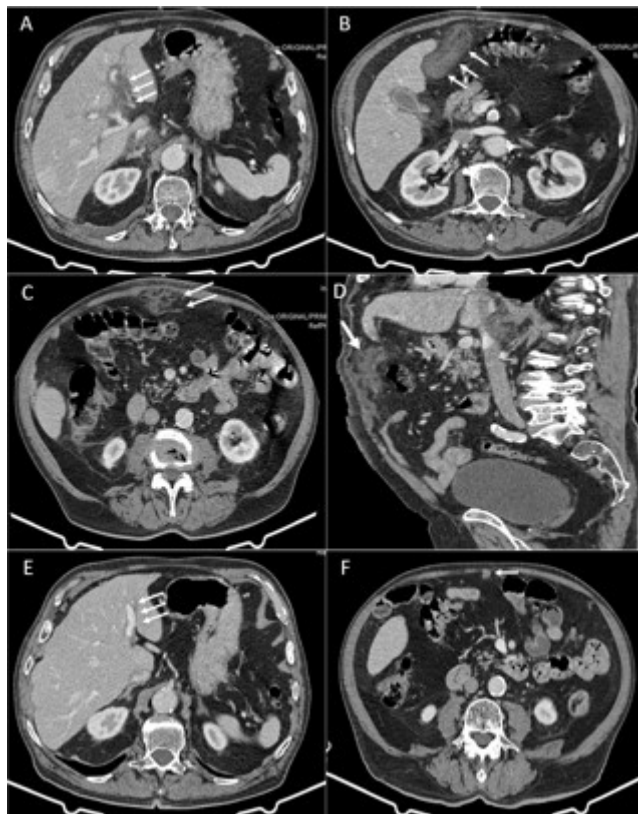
Images of abdomino-pelvic CT with contrast. *A, B, C and D.* Cross-sections in which extensive inflammatory infiltrate of fat (arrows) is observed around the portal bifurcation and the left portal ramus slightly stenosing the left intrahepatic radicals and extending along the entire route of the falciform ligament to the umbilical region. *E and F.* Cross-sections in which significant improvement of the entire inflammatory process (arrows) after treatment.
